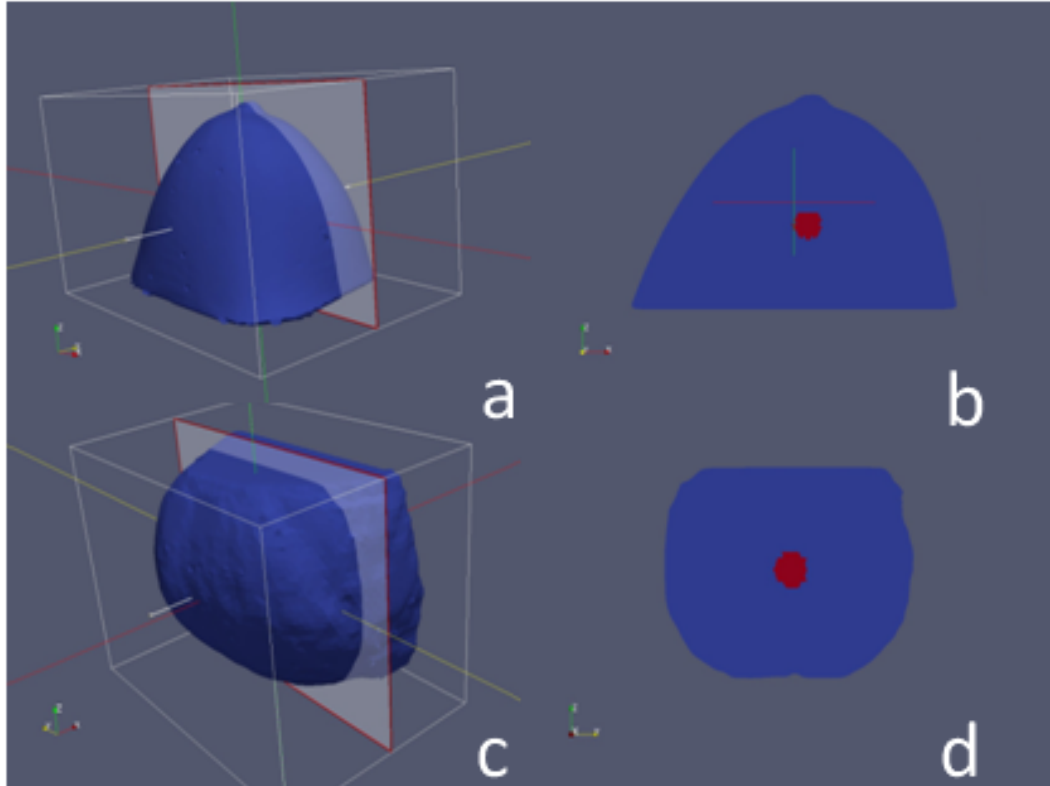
Source CT mesh (a) with cross-section showing tumor-to-normal elasticity contrast (b), and source MR mesh (c) with cross-section showing similar contrast (d).
